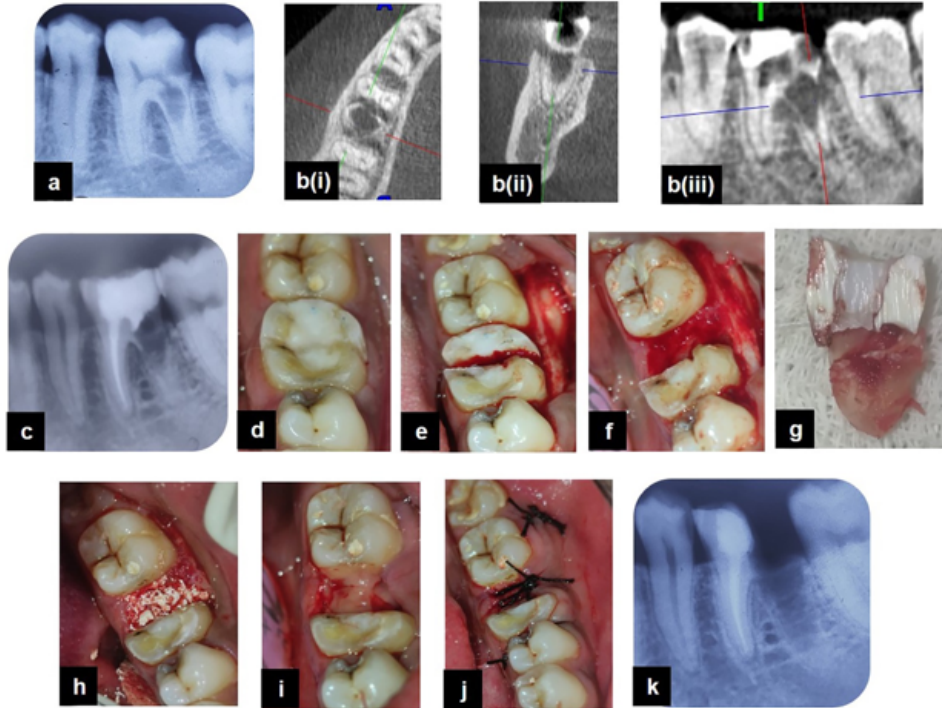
Procedural steps of hemisectomy in mandibular first molar: (a): Pre-operative radiograph, (b): Pre-operative CBCT views i): Axial, ii): Coronal; iii): Sagittal, (c): Post-obturation radiograph, (d) post-obturation clinical view, (e): Tooth sectioning, (f): Hemisectomised tooth, (g): Resected distal portion,(h): PRF and bone graft placement, (i): PRF membrane placement, (j): Sutures placed; (k): Post-operative radiograph
